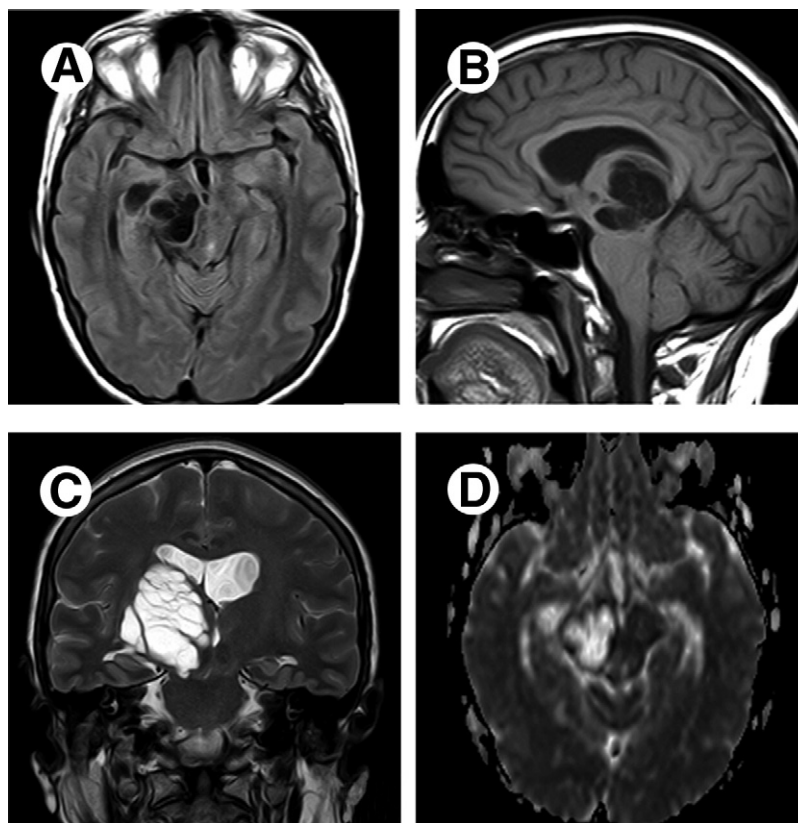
Enlarged VR spaces. Sagittal T1-weighted image (A) shows clusters of isointense variable-sized cysts with CSF in the midbrain. Axial FLAIR (B) shows a CSF-suppressed signal within the cysts. Coronal TSE T2-weighted imaged (C) demonstrates expansion and mass effect laterally in the third ventricle. ADC map (D) reveals increased water diffusion of the lesions.
